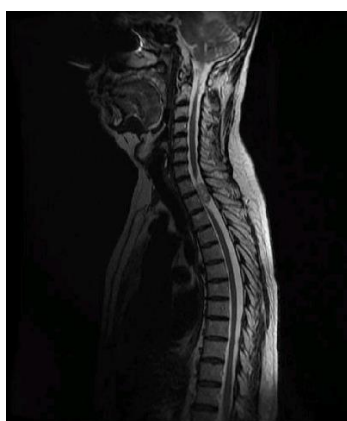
T2 MRI sagittal view showing tumor at Th 1-2 level.
